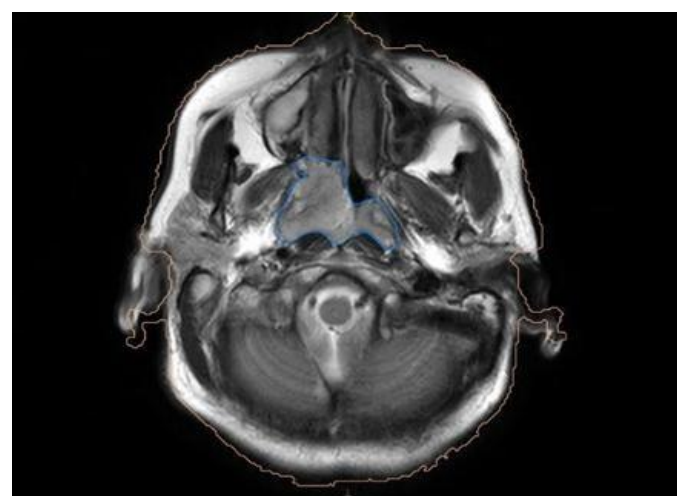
GTV Delineation Using CT and MRI Fusion
